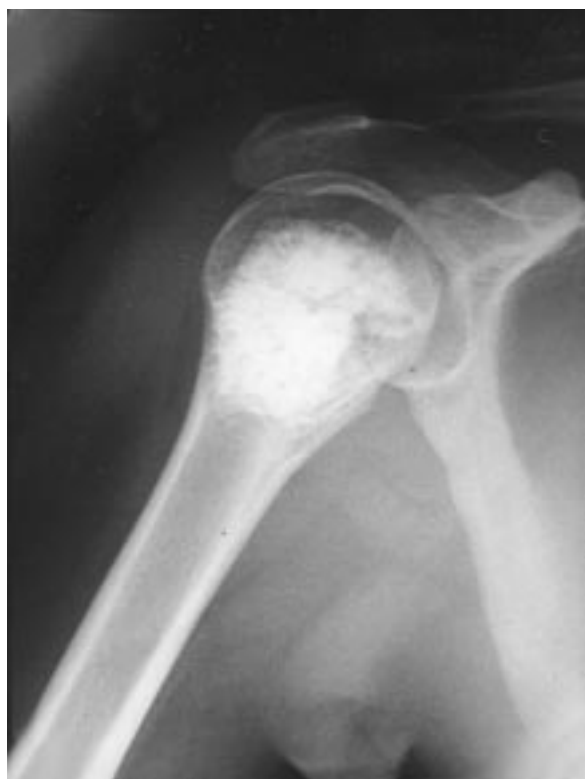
Giant cell tumor grade 2 filled with Eurocer 400* and Eurocer 200*: radiograph after 9 months.
